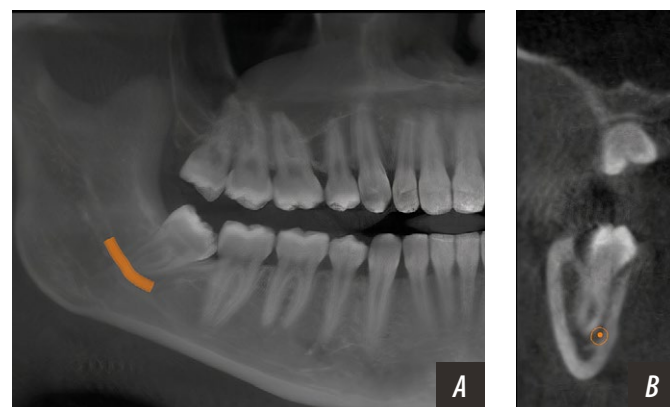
Root darkening in the panoramic radiography (A). Transaxial section in the cone beam computer tomography shows IDC in lingual position to root apex with direct contact with the distal root of MTM (B)
